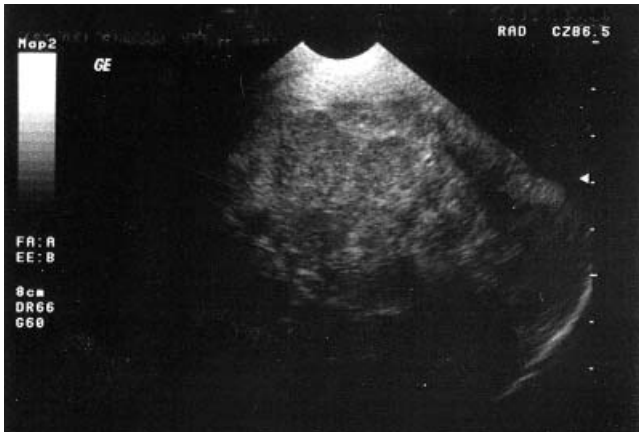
Sonogram of the left testis showing thin hyperechoic bundles
